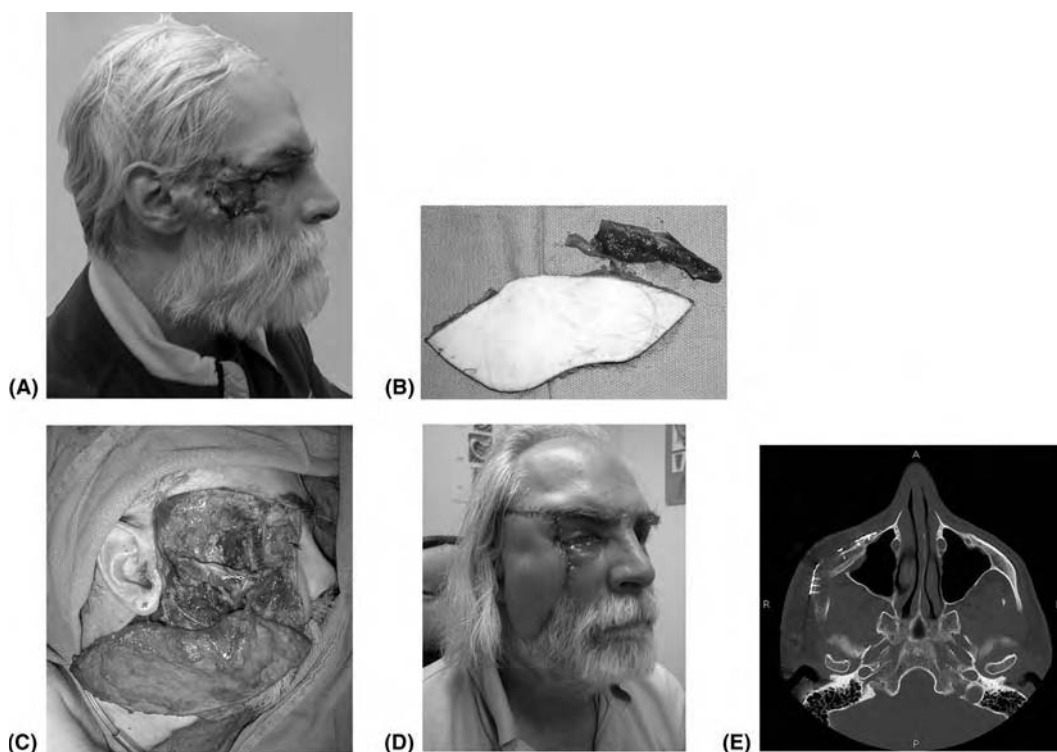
(A) A 49-year-old man with extensive neglected basal cell carcinoma of left cheek with involvement of underlying zygoma and lateral orbit. (B) Scapular osseocutaneous free flap harvested. (C) Bony reconstruction (see miniplate) with vascularized scapula. The skin paddle is at the bottom of the picture and the pedicle can be seen extending from the bone into the skin paddle. (D) Immediate postoperative appearance. (E) Postoperative CT scan showing position of bony reconstruction.
